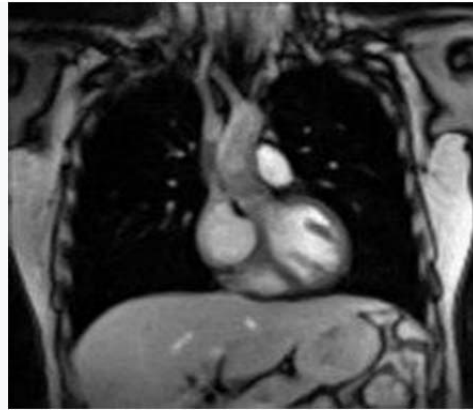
Real-time magnetic resonance imaging (MRI) of the chest movements of human thorax during breathing. The "pumps handle" and "bucket handle movements" of the ribs
